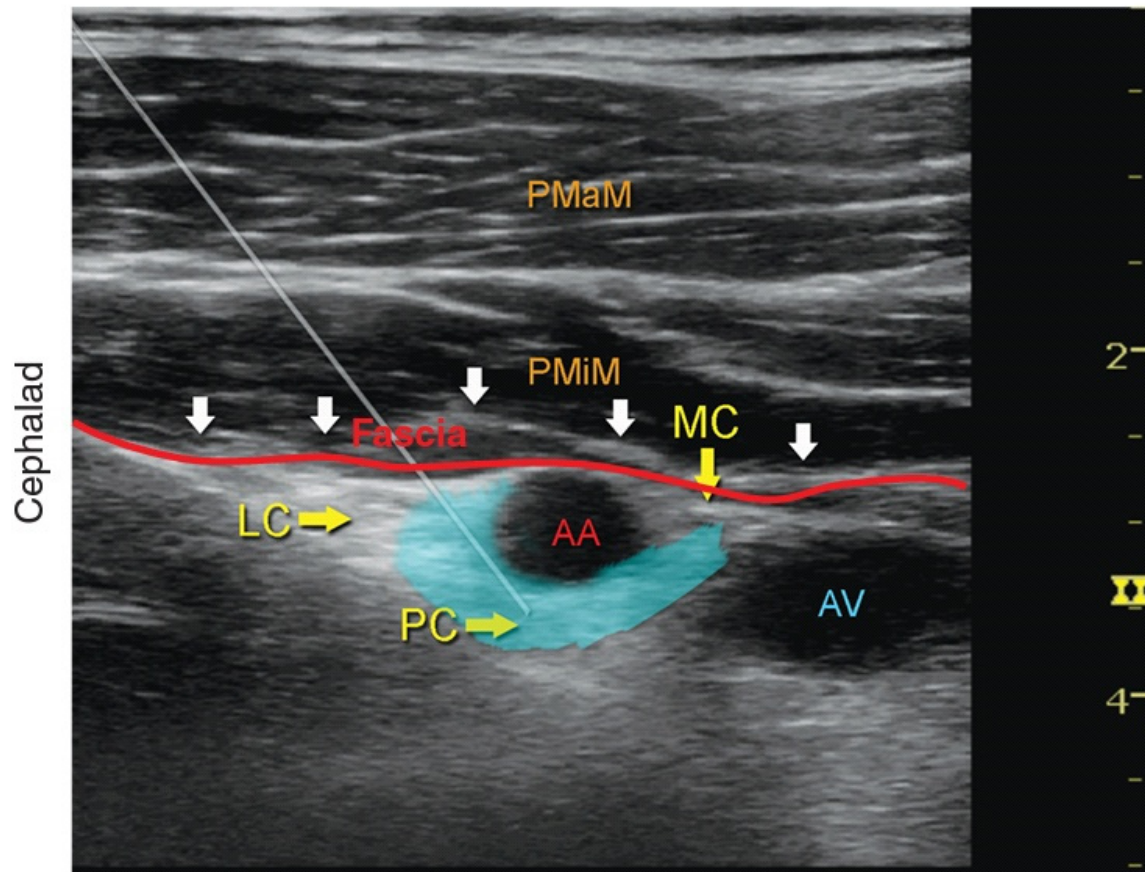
Sonographic image demonstrating needle path
